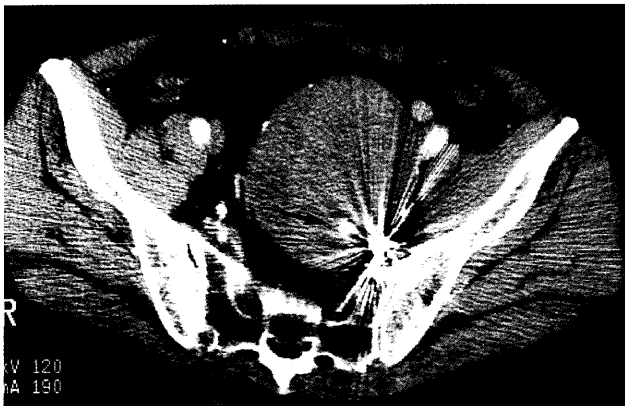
CT scan 24 months after the stent-grafting shows increased aneurysmal size and minor contrast opacifications (arrow) in the internal iliac artery aneurysm.
